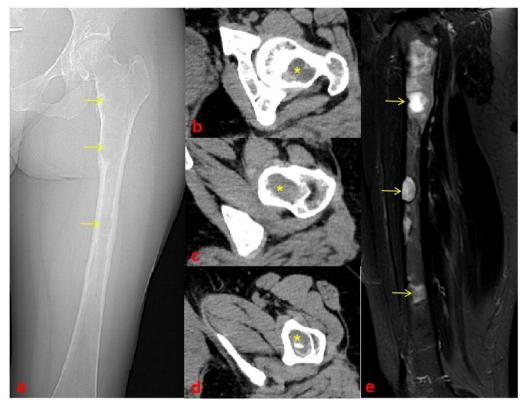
Fibrous dysplasia accompanied with bone cyst in Patient 2. A Preoperative radiographic image showed multiple lesion sites with a ground-glass appearance (yellow arrows) in the femur bone for Patient 2. B–D Preoperative axial computed tomography images showed the appearance of lesion sites in the marrow cavity of the proximal femur bone (yellow asterisks). E Preoperative magnetic resonance imaging. The preoperative sagittal T2-weighted image showed multiple high intensities in the medullary space of the femur bone (yellow arrows)
